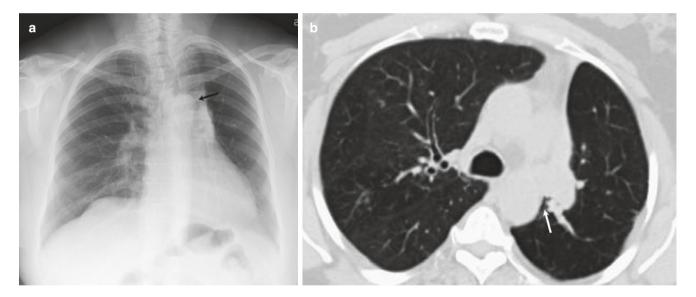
Left upper lobe collapse. (a) Frontal radiograph reveals a left upper paramediastinal opacity, pulling trachea toward it. The hyperexpanded superior segment of the left lower lobe insinuates itself between the left upper lobe and the superior mediastinum, sharply silhouetting
